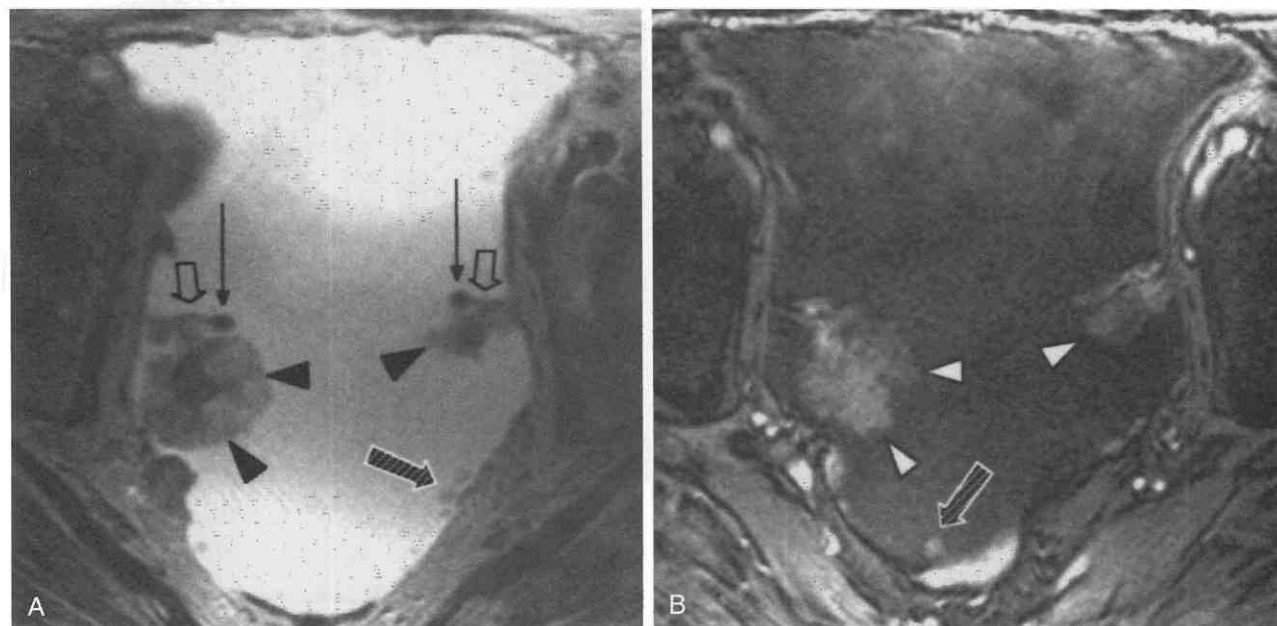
Marked ascites and bilateral ovarian surface implants of papillary serous carcinoma (*arrowheads*). *A*, T2-weighted, fast spin-echo image shows the normal fallopian tubes (*thin arrows*) attached to the broad ligaments (*open arrows*) by the thin mesosalpinges. *Arrowheads* point to implants of papillary ovarian cancer coating the surfaces above the ovaries. *Hatched arrow* points to nodular implants of papillary tumor in the cul-de-sac. *B*, Gadolinium-enhanced, T1-weighted, gradient-echo image demonstrates enhancement of the papillary tumor on the surface of the ovaries (*arrowheads*) and in the cul-de-sac (*hatched arrow*). (From Ascher SM, Outwater EK, Reinhold C: Adnexa. In Semelka RC, Ascher SM, Reinhold C [eds]: MRI of the Abdomen and Pelvis: A Text-Atlas. New York, Wiley-Liss, 1997, pp 661–715.¹²)
